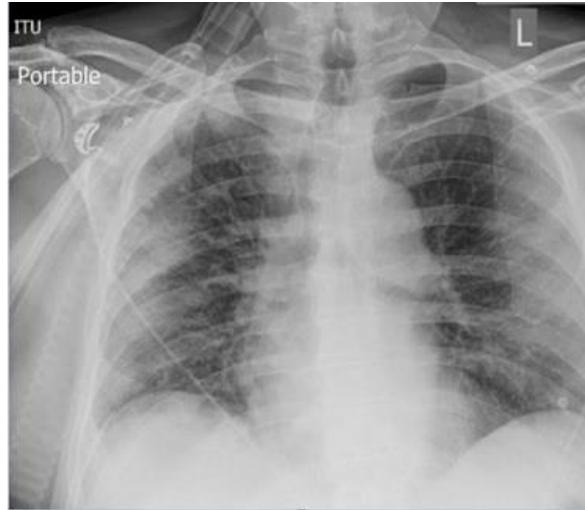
Chest X-ray showing peripheral ground-glass opacities involving both lower lobes
